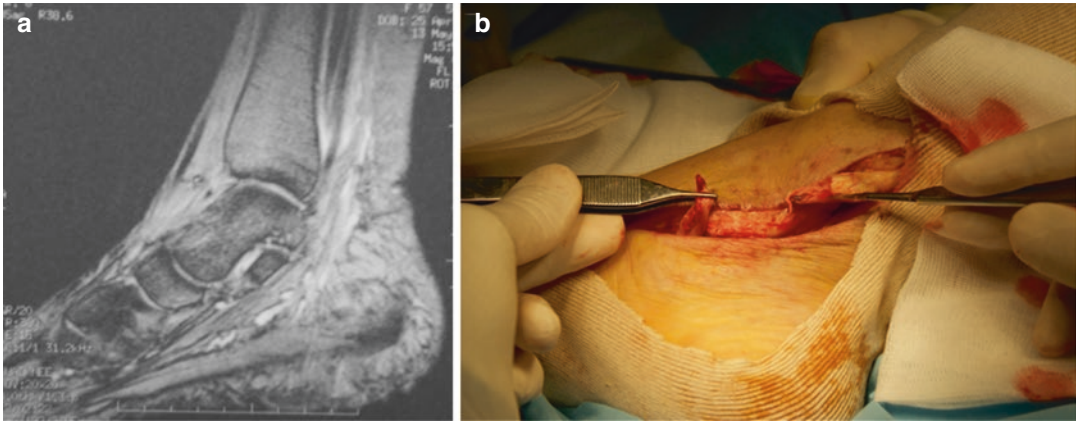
Posterior tibial tendon rupture on MRI (a) and direct surgical repair (b) which was further augmented by *flexor digitorum longus* transfer
